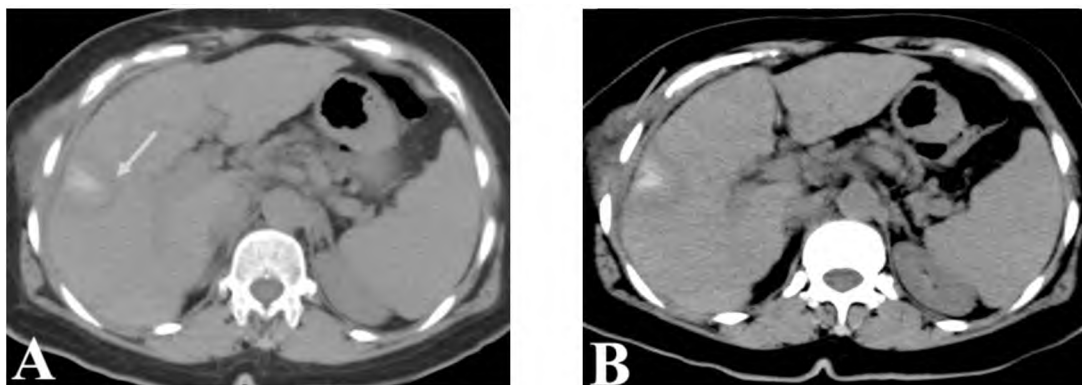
A female patient aged 63 years old with hepatitis C cirrhosis presented by right liver lobe HCC. Two weeks follow-up triphasic CT of the abdomen revealed complete response to the ablation with no residual HCC lesions and subcutaneous and muscular burn related to the site of micro-wave needle insertion. (A&B): Non-contrast CT abdomen showing a well defined hypo-dense focal lesion in the right lobe segment VIII (Yellow arrow) measuring 3.5 x 3.2cm, with surrounding subcutaneous and muscular burn (Red arrow).
